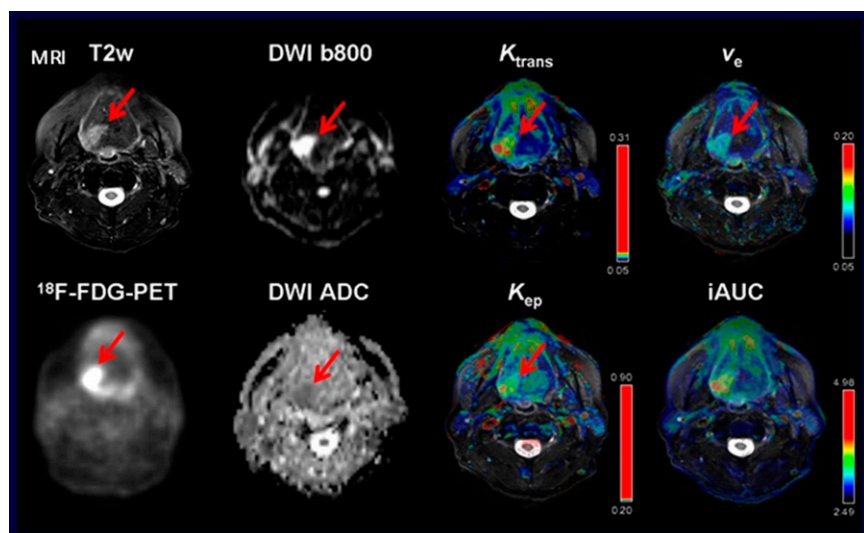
^{18}F -FDG PET/MR of a patient with head and neck cancer. Top row (left to right): T2-weighted MR; diffusion-weighted MR; transfer constant (k_{trans}) MR map; interstitial volume (v_e) MR map. Bottom row (left to right): ^{18}F -FDG PET; diffusion-weighted apparent diffusion coefficient MR; rate constant (k_{ep}) MR map; initial area under the uptake curve (iAUC) contrast-enhanced MR.
